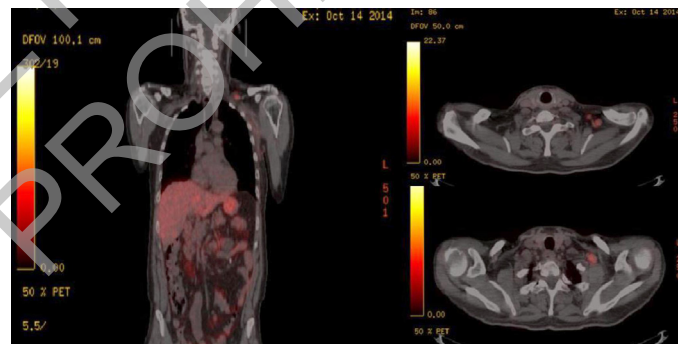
Ga68 PET/CT scan – Post Lu177 progressive disease.
